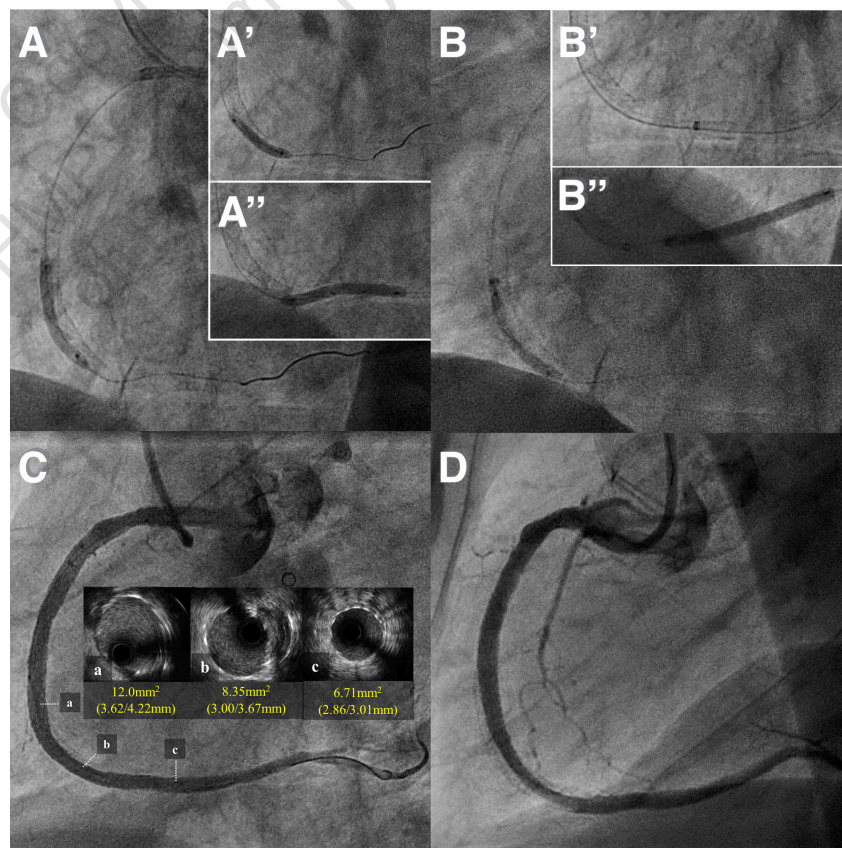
[A] Subadventitial crushing of the occluded stents is performed with 2.5 mm balloons. [B] A 7 Fr GuideLiner is advanced to the distal right coronary artery [RCA] through the subadventitial space using the stepwise repeated distal balloon anchoring technique.⁷ Five drug-eluting stents were implanted from the posterolateral branch to the RCA ostium, with optimal angiographic result confirmed with intravascular ultrasound imaging [C and D]. Note the much larger final lumen diameter [C] compared with the baseline situation shown in Figure 2.
